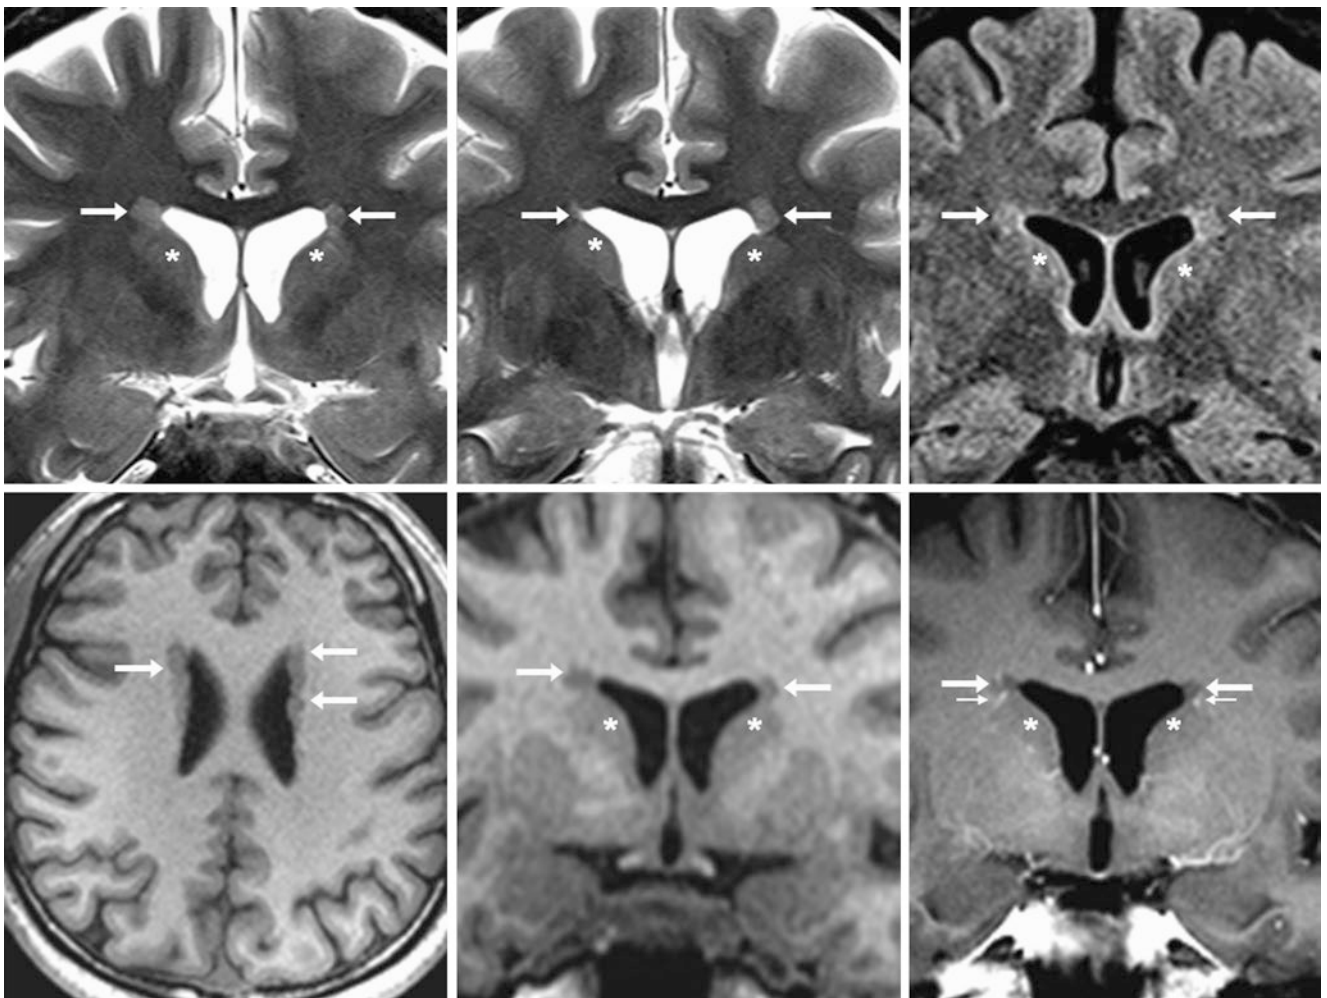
Comparison case of bilateral PVNH. In a 19 year old with seizures, a 3 T MRI with coronal T2WIs (*top left and middle*) showed bilateral gray matter-like nodular foci (*arrows*) just above the caudate nuclei (*) but difficult to visualize on FLAIR (*top right*). Axial T1WI (*bottom left*) confirmed the nodularity of these foci, although the nodular appearance was more difficult to discern on coronal T1WI (*bottom middle*). The faint enhancement noted just outside of these lesions (*tiny arrows*), rather than within them, is typical of PEP/ependymitis granularis
